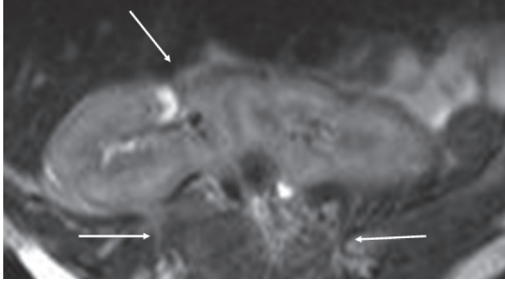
The axial T2-weighted image of the spine shows a lobulated mass of more smaller formations which correspond to the supernumerary vertebrae. The image also shows a ren arcuatus.
